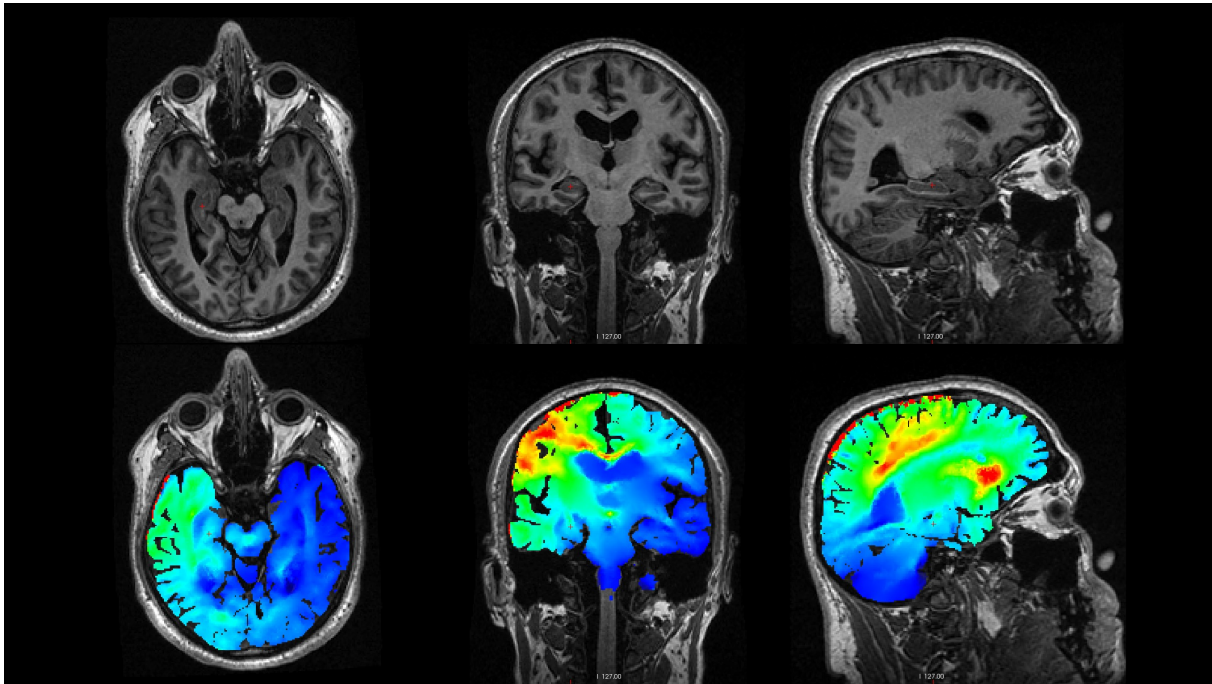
Random participant, MRI 1. Top: Axial, coronal and sagittal view of a T1-weighted MRI (orig.mgz). Bottom: Axial, coronal and sagittal view of the EF strength in a brain (emag.mgz masked with aseg.mgz). The minor red cursor points at the right hippocampus.
